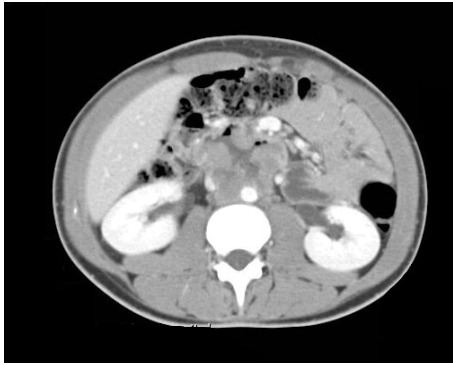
Prechemotherapy CT of the abdomen reveals soft tissue necrotic mass measuring 4.6 x 5cm in and is inseparable from the third part of the duodenum encasing the aorta, displacing and compressing the inferior vena cava.
